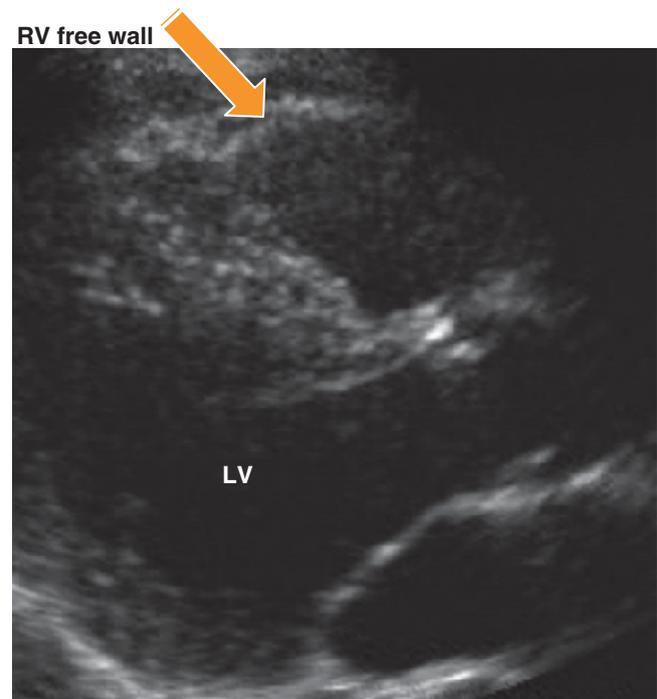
Parasternal long-axis projection from a patient with ventricular tachycardia demonstrating a non-dilated RV outflow, but a localized RV free wall thinning (arrow) and absent contraction, suggestive of ARVC/D
